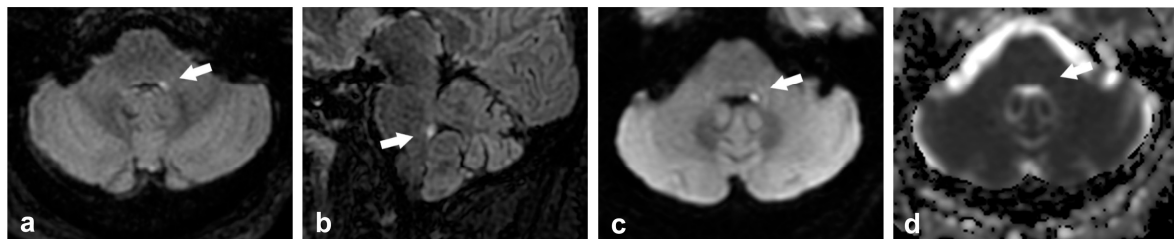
Neuroimaging findings in a 57-year-old patient with an acute small stroke in the left ICP. He presented to the emergency room with acute binocular diplopia, cephalic and gait instability, motion sickness, and vomiting. (a) Axial T2 FLAIR image that shows a small hyperintense foci in the left ICP (arrow), (b) sagittal T2 FLAIR image at the level of the hyperintense foci in the ICP (arrow), (c) axial DWI sequence, and (d) axial ADC sequence shows subtle restriction to diffusion (arrows).
